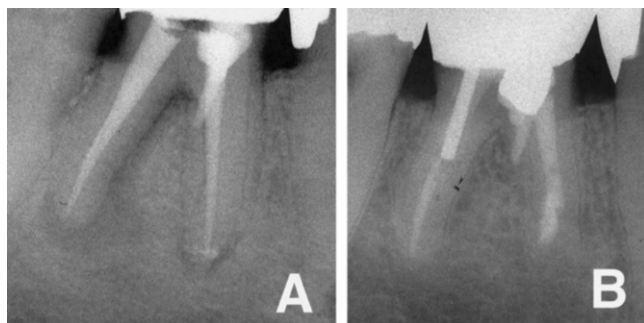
Radiographs of the mandibular right first molar with a perforation of the furcation region. *A*, Postoperative radiograph taken immediately after the repair of the perforation. *B*, Radiograph taken 45 months after perforation repair.
